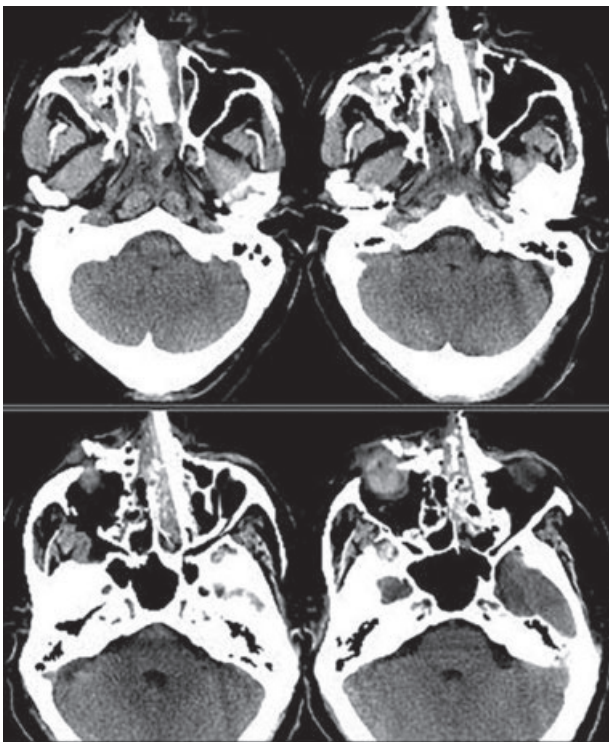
CT scan of the face region showing trajectory of the broken pipe that has entered into the right nostril and penetrated toward the left side.
